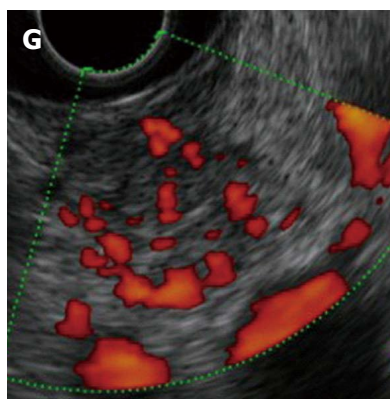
Images of the pancreatic tumour. A: Dynamic computed tomography (CT) in the arterial phase; B: Dynamic CT in the portal phase. 1.5-cm well demarcated tumour at the pancreas head was very strongly enhanced in the arterial phase and still faintly enhanced in the portal phase; C: Maximum intensity projection of the arterial phase in a coronal view. Black arrow indicates the feeding artery from the inferior pancreaticoduodenal artery and white arrow indicates the draining vein into the portal vein; D: T1-weighted (T1W) magnetic resonance image (MRI); E: T2-weighted (T2W) MRI. The tumour appeared as a low-intensity lesion in T1W and as a high-intensity lesion in T2W; F: Endoscopic ultrasonography (EUS) images without power flow scanning; G: EUS images with power flow scanning. The low and uneven echoic tumour was surrounded by draining vessels.
